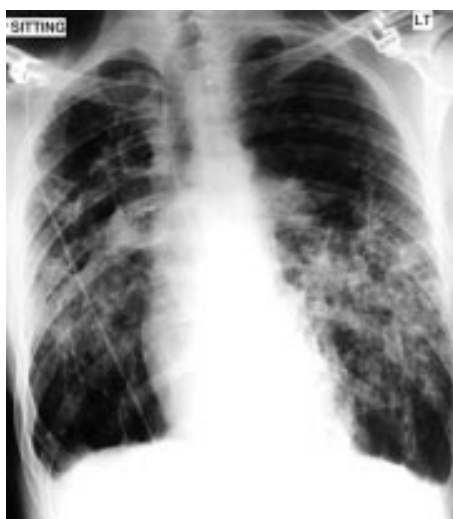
Chest radiograph consistent with underlying histiocytosis X but no obvious pneumothorax.
